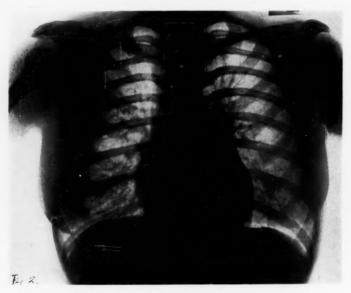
X-ray four months after onset of treatment showing atelectatic lung expanded.
